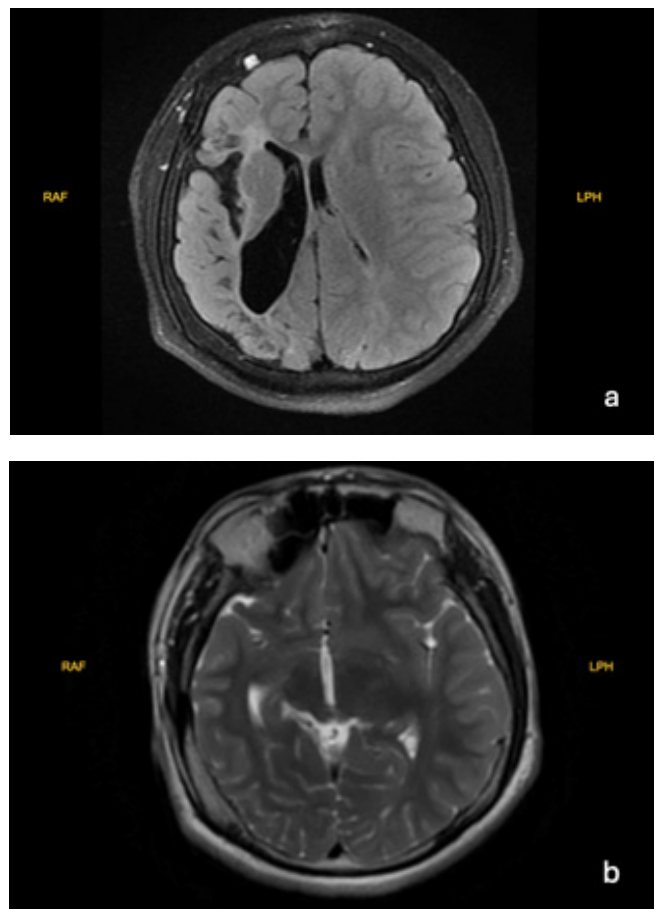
Cranial magnetic resonance imaging shows encephalomalacic changes in the right occipital, temporal, and frontal regions accompanied by thickening in the right hemiclavicular bone structures in a; increased aeration of the frontal sinuses is observed in b.
